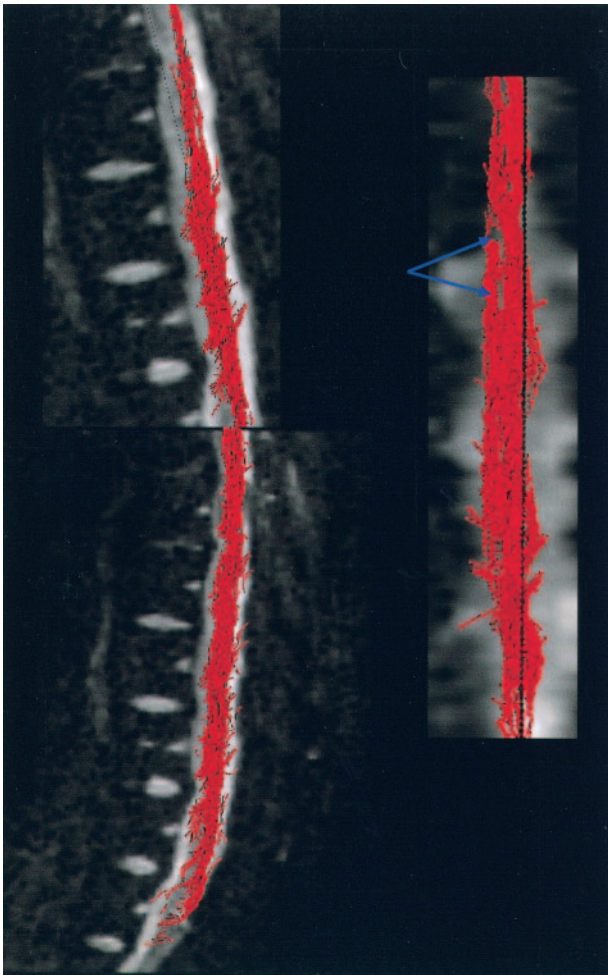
Three-dimensional reconstructions are mapped over the b_0 images. Fiber tracking performed on the spinal cord volunteer shows some pitfalls of the FT method due to magnetic susceptibility effect of the DTI MR image: "hole" effect, gap in three-dimensional reconstruction (blue arrows).
